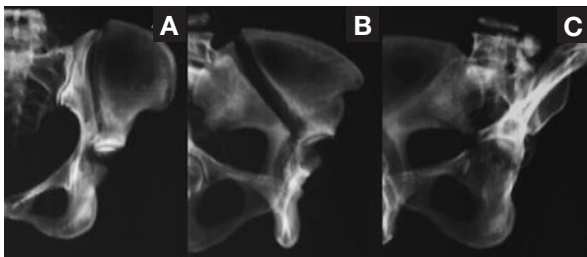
Anteroposterior (A), iliac oblique (B), and obturator oblique (C) computer-reconstructed radiographs of the anterior column fracture shown in Figures 1A–1C. Femoral head and proximal femur have been removed.
